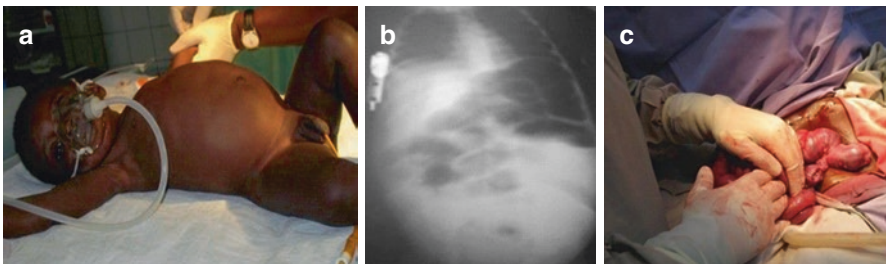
Ileocolic intussusception. (a) Depicts a young child at presentation with abdominal distension; (b) x-ray findings at presentation; (c) the intraoperative findings of the ileocolic intussusception
